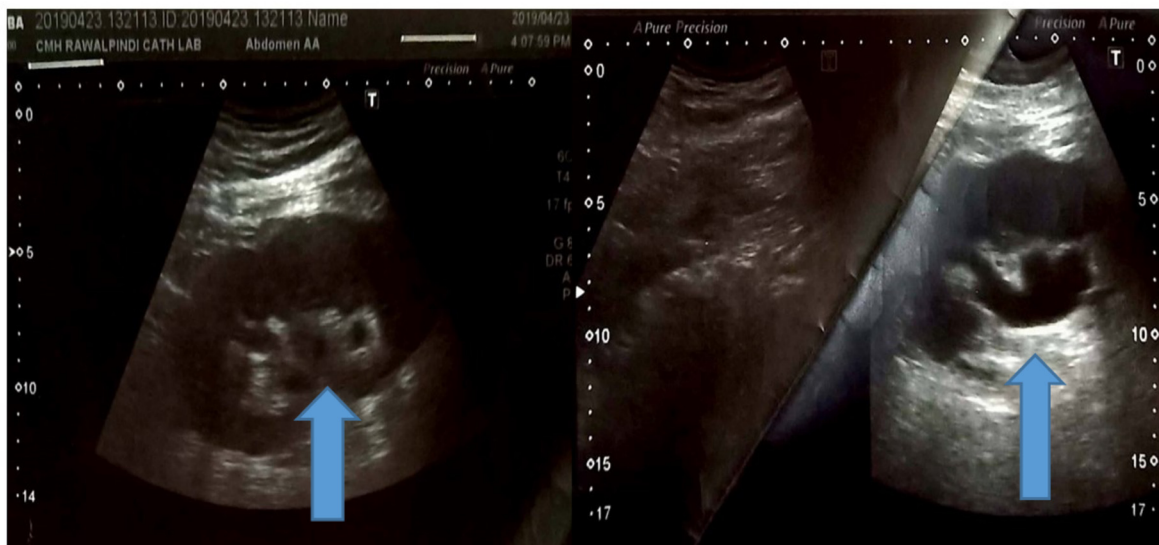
Ultrasonography showing minimal fullness of system and intraparenchymal gas.
